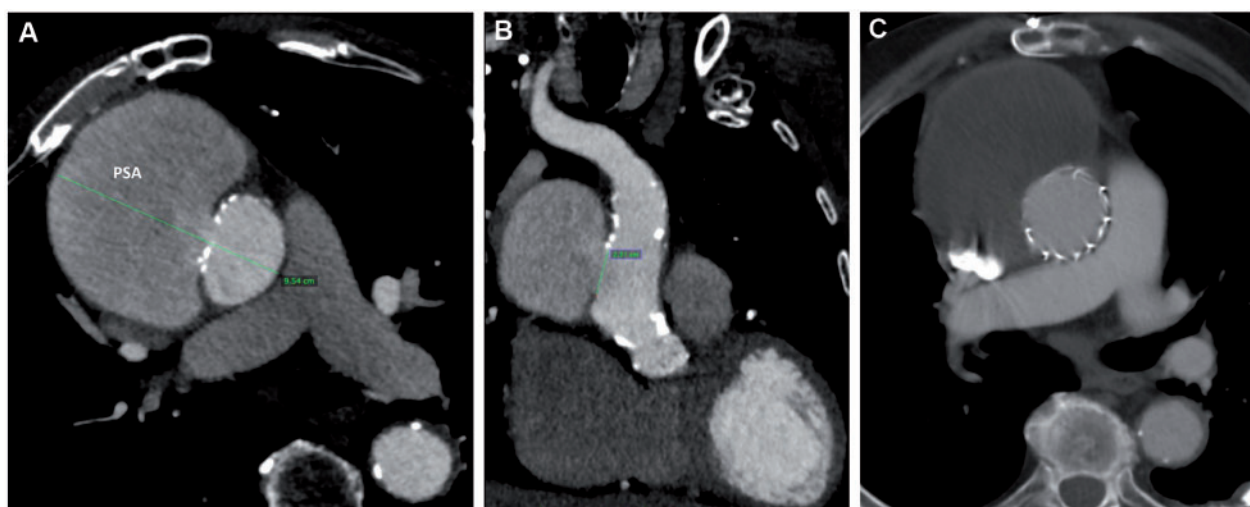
Preoperative computed tomography angiography (A) with multiplanar (B) reconstruction of a 66-year-old male with a huge pseudoaneurysm originating from the cannulation site of a previous coronary artery bypass graft. Follow-up computed tomography angiography (C) at 38 months shows complete thrombosis of the pseudoaneurysm.
